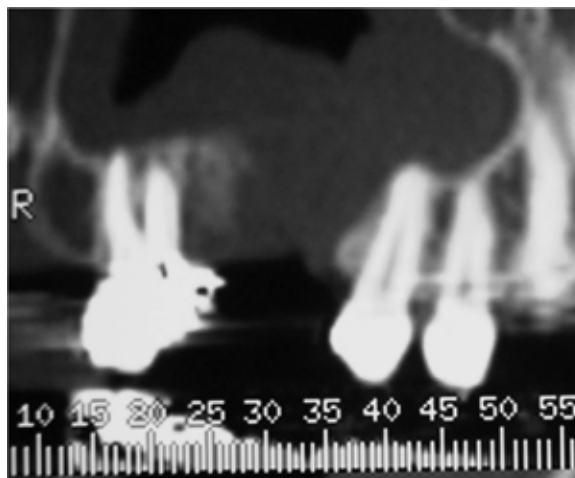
Computed tomography image revealing an OAC of 8 mm size with chronic sinusitis (case 2).
